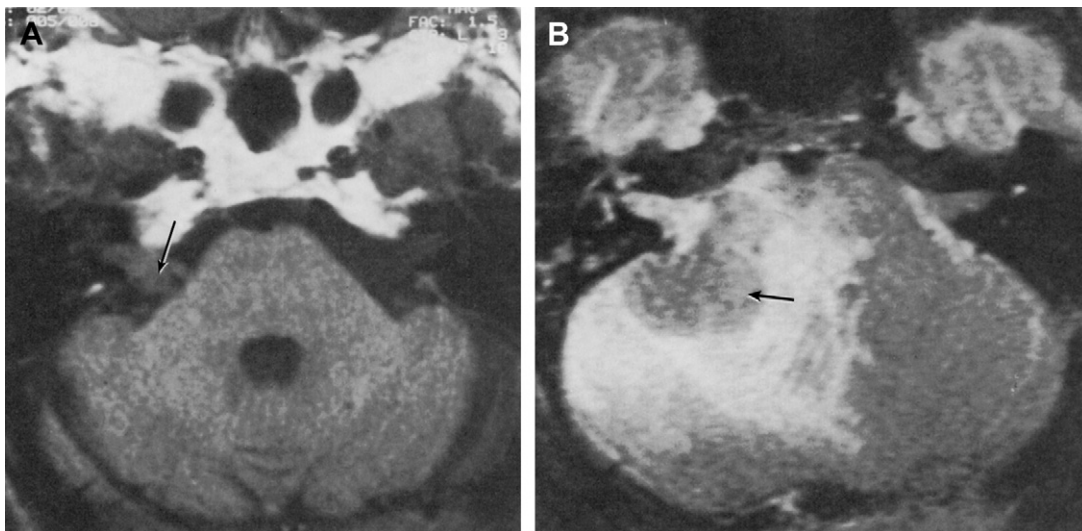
Metastases to the internal auditory canal with facial nerve paralysis and hearing loss. (A) T₁-weighted image without gadolinium shows a soft tissue mass (*arrow*) filling the porus and protruding into the CPA cistern (*arrow*). Computed tomography scan showed slight enlargement of the facial nerve canal (not shown). (B) Two months later there is a considerable increase in symptoms. The mass (*arrow*) has increased in size. There is shift of the brain stem and considerable edema in the brain contiguous with the lesion.
